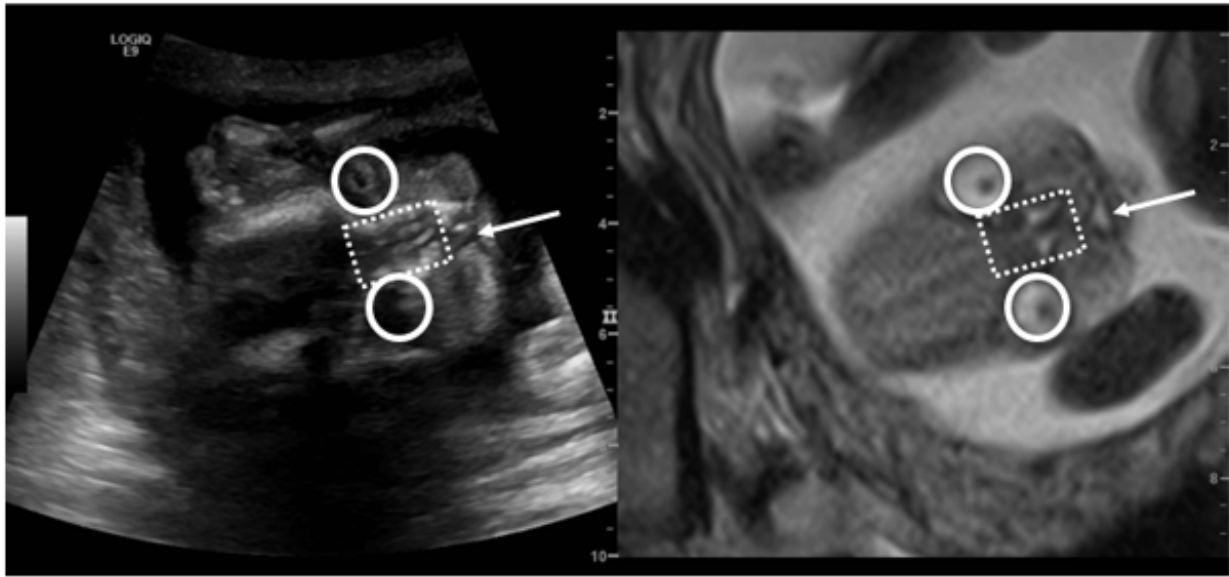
Fusion image of a sonographic and MR image in the coronal plane of a fetus at 22 weeks of gestation. In this image, the face with the eyes (white circles) and nasal cavity (white cubicle) are seen with a unilateral cleft lip (white arrow).
